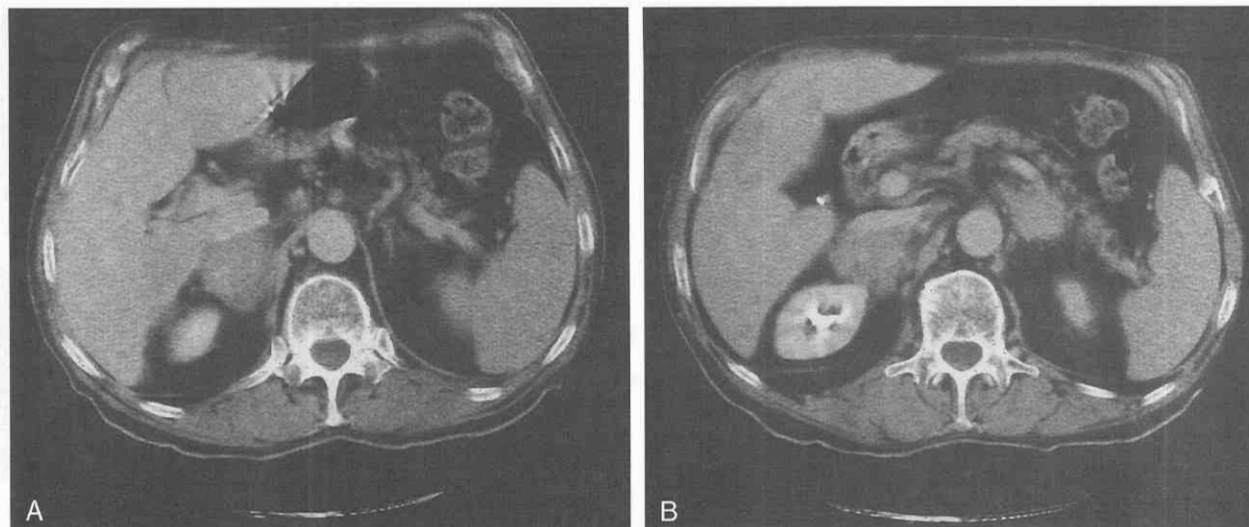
Lymphoma. *A* and *B*, Contrast-enhanced CT scans of the abdomen demonstrate bilateral infiltrating soft tissue masses within both adrenal glands. The appearance is compatible with that of a lymphoma. Involvement of the liver can be seen on the lower-level scan of the series. The patient underwent percutaneous adrenal biopsy, which resulted in a diagnosis of non-Hodgkin's lymphoma.
